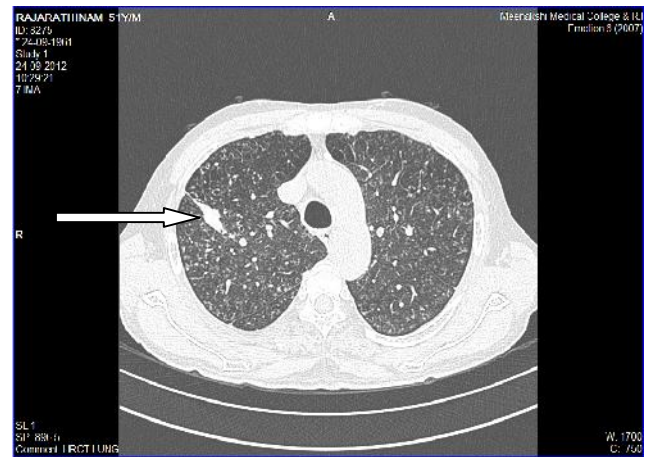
HRCT Chest showing a conglomerate nodule in the apicoposterior segment with reticulonodular opacities.
